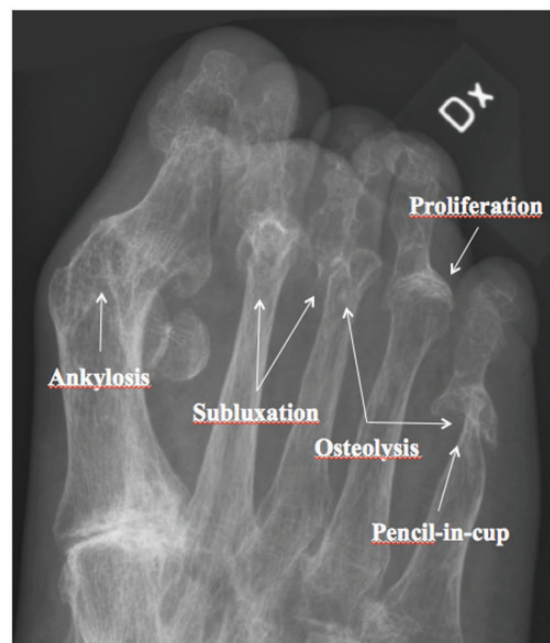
Radiography of a 66-year-old female patient with psoriatic arthritis mutilans with a history psoriatic arthritis of 27 years with all the five classical sign of arthritis mutilans.
